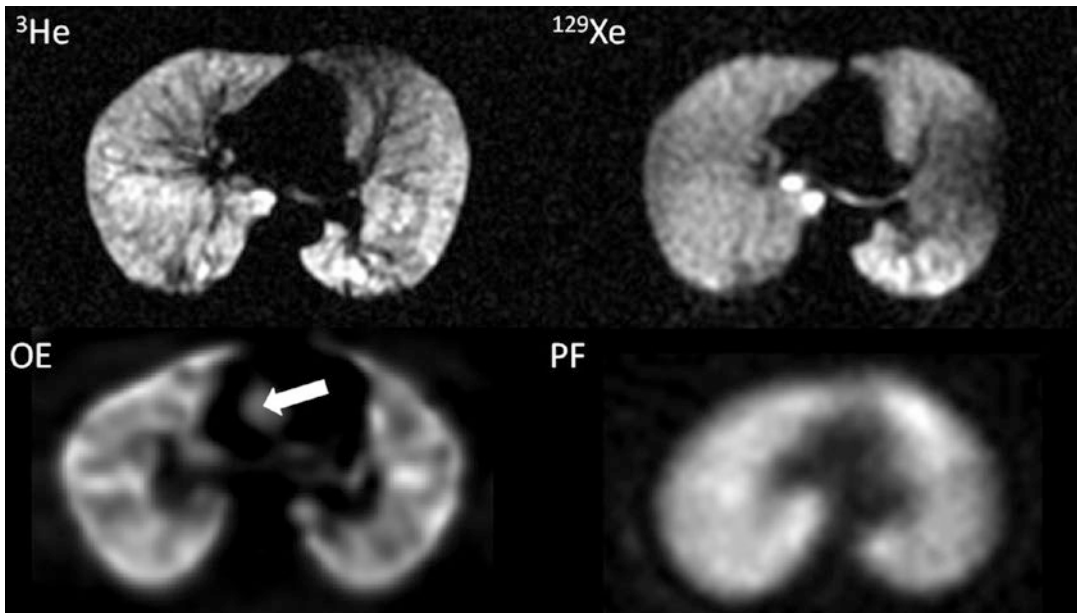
Representative images of the four main gas agents used in ventilation-weighted MRI: helium-3, xenon-129, oxygen-enhanced (*OE*) and perfluorinated gas (*PF*). The *PF* image is adapted from (Kruger et al. 2016). In the *OE*
